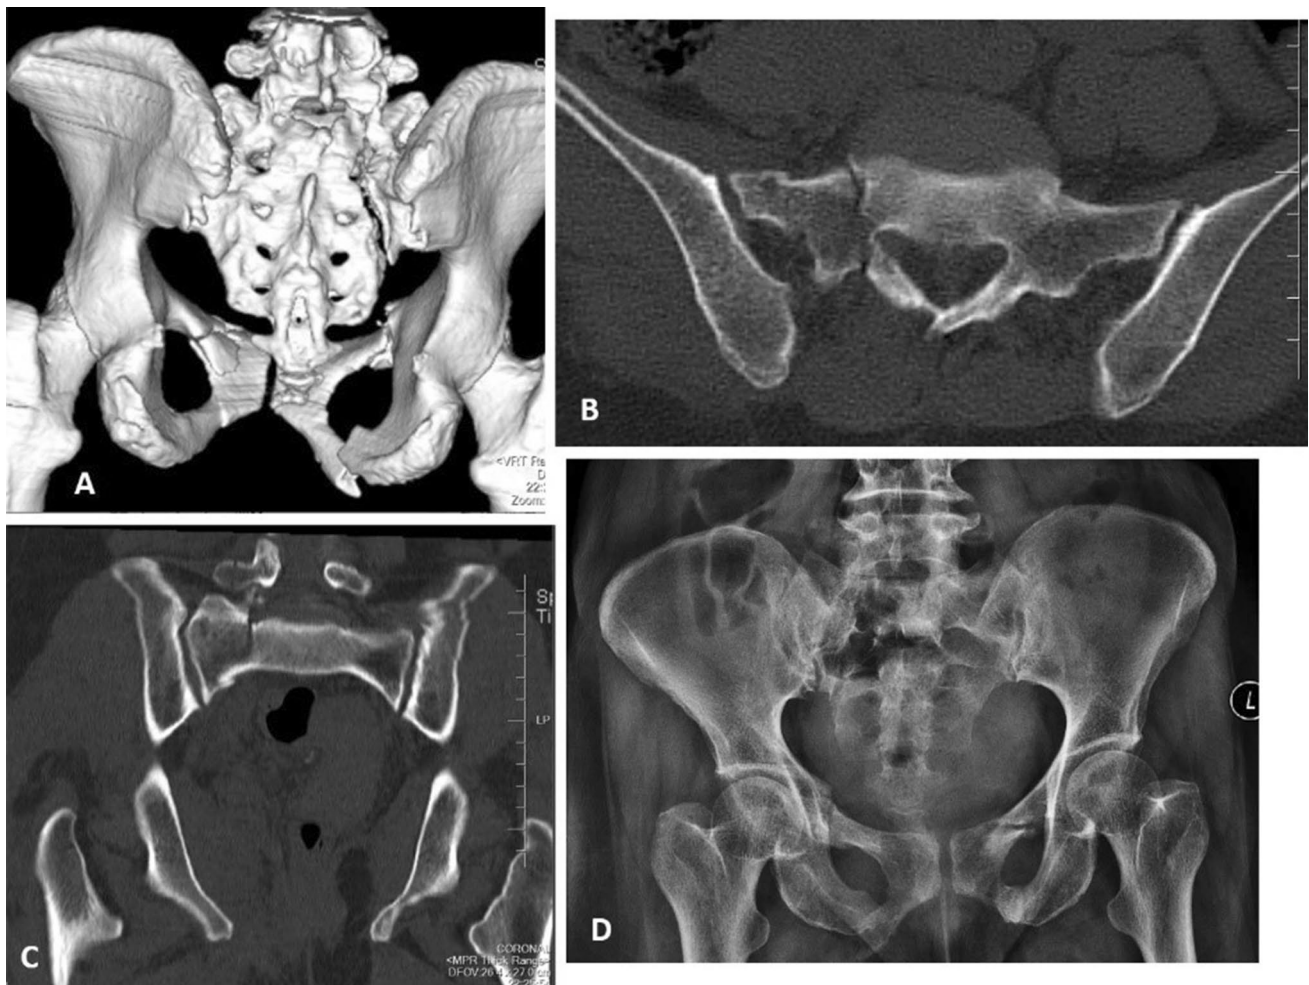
3D reconstructed CT image (A), axial CT (B) and coronal CT (C) sections show a vertical fracture line passing through the S1 facet (Isler's type 2a). Fractures through both pubic rami are visualised. D Follow-up pelvis AP X-ray at the end of 8 months shows a healed fracture
